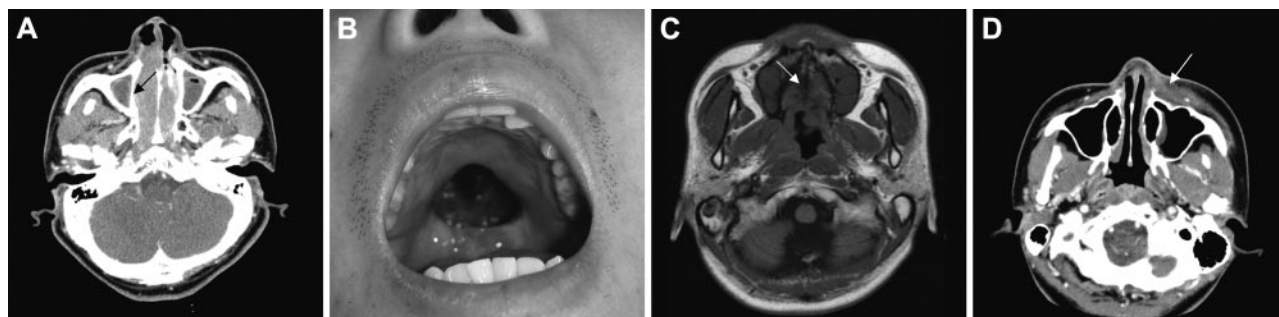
Local tumor invasiveness. (A) Thinning of right medial wall of maxillary bone (arrow) in CT of paranasal sinuses. (B) Palatal perforation on physical examination. (C) High signal intensity of hard palate is not delineated in T1-weighted MRI (arrow). (D) Skin infiltration by tumor (arrow) in CT of paranasal sinuses. Picture was taken with an Olympus Camedia C4000Z camera (Olympus, Tokyo, Japan). Adobe Photoshop 6.0 was used to process images (Adobe, San Jose, CA).
